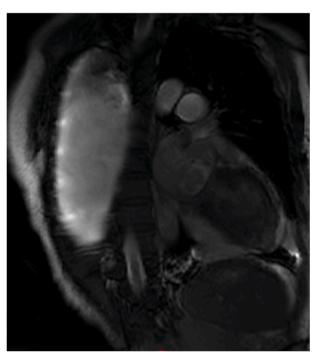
2 chamber view MRI.
